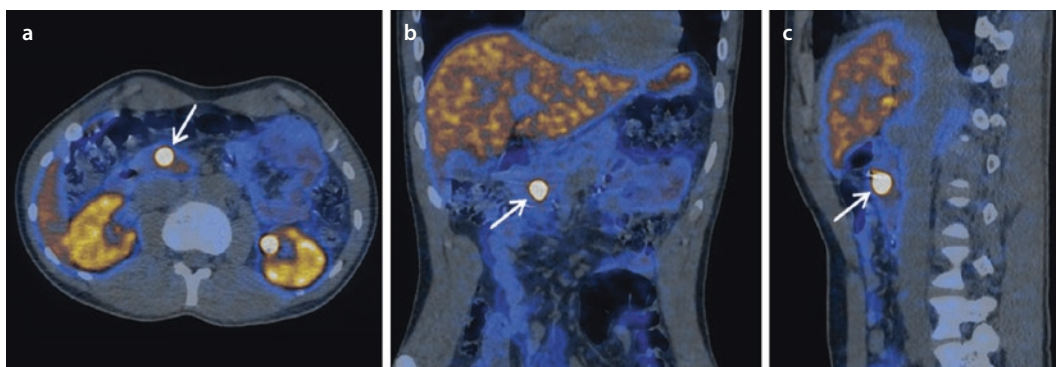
Axial a, transverse b, and sagittal c fused [^{68}Ga]Ga-DOTATATE PET/CT images of a pancreatic (insulinoma) (arrows)
